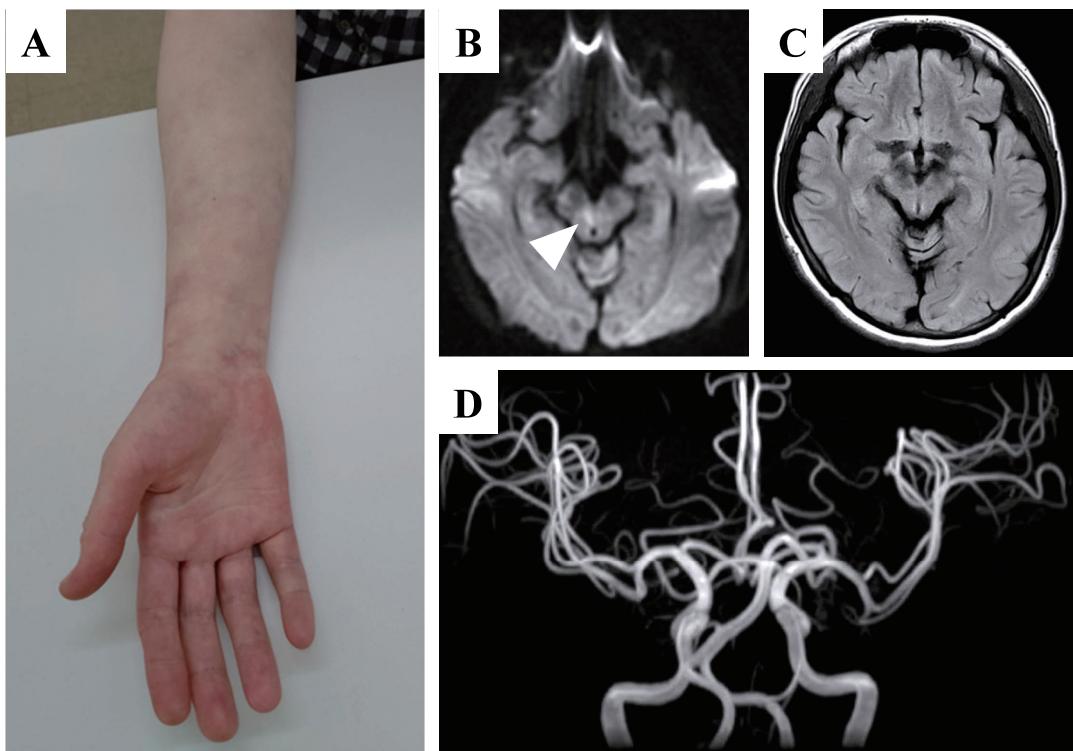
(A) The patient's right forearm at the age of 42 years showing a mild livedo-like rash. (B) Diffusion-weighted brain MRI at the age of 28 years demonstrating a high-intensity lesion in the right medial midbrain. (C) Fluid attenuated inversion recovery imaging of brain MRI at the age of 42 years, showing no apparent increase in lesion size or quantity. (D) MR angiography at the age of 42 years, showing no significant stenosis or occlusion of the major intracranial arteries.
